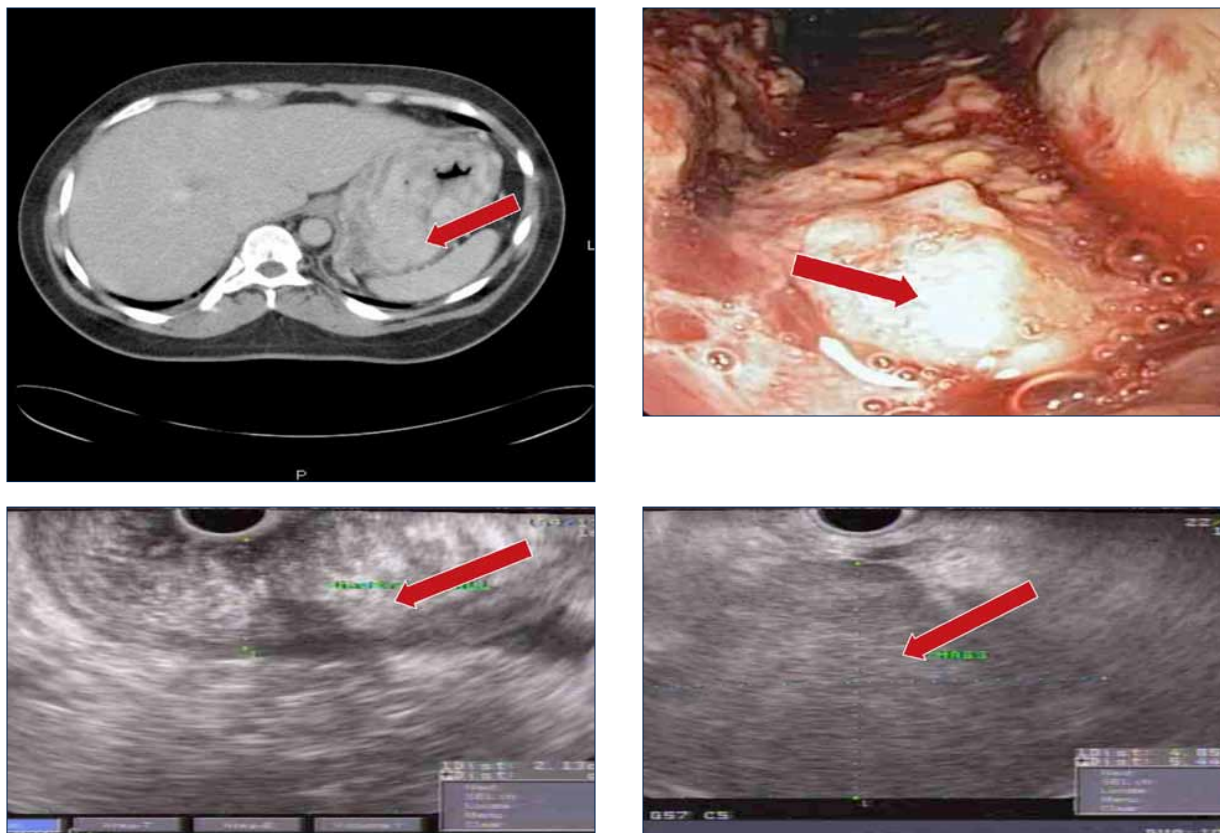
A) Computed tomography (CT) scan showing stomach wall thickening and a large mass. B) Upper gastrointestinal (GI) endoscopy depicting the infiltrating stomach mass. C) Endoscopic ultrasound showing thickened stomach wall. D) Endoscopic ultrasound showing the adrenal mass.
